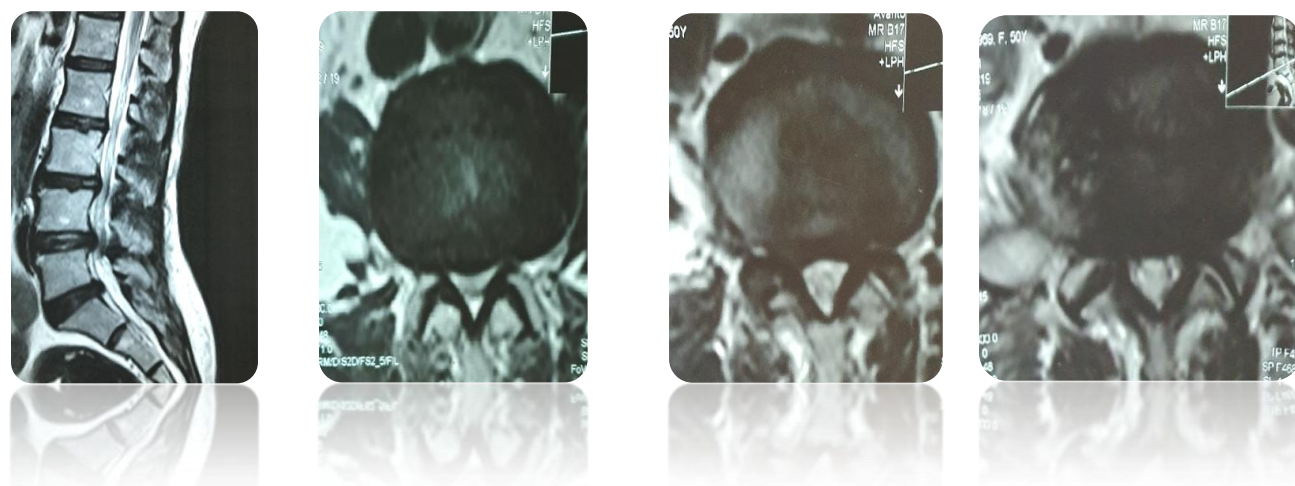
Pre-operative MRI of Lumbosacral spine sagittal and axial section of T2 weighted image
